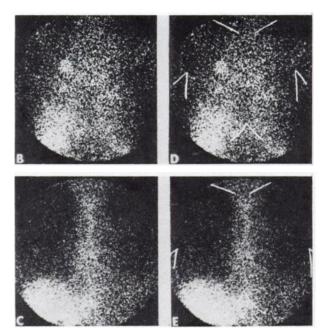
Patient with planocellular cancer in right upper lobe of lung. (A) Chest x-ray; (B) anterior scintigram of thorax taken with <sup>57</sup>Co-bleomycin shows concentration in tumor; (C) similar scan taken with <sup>111</sup>In-bleomycin 72 hr after injection shows no concentration in tumor. (D and E) Same scintigrams with lines marking axillae, clavicles, and xiphoid process.
